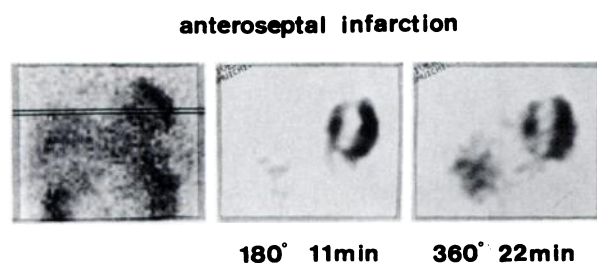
SPECT images in a single transaxial plane, reconstructed from 180 and 360° data collection, in a patient with anteroseptal infarction. Perfusion defect is seen more clearly in 180° projection, with greatly reduced background noise.
